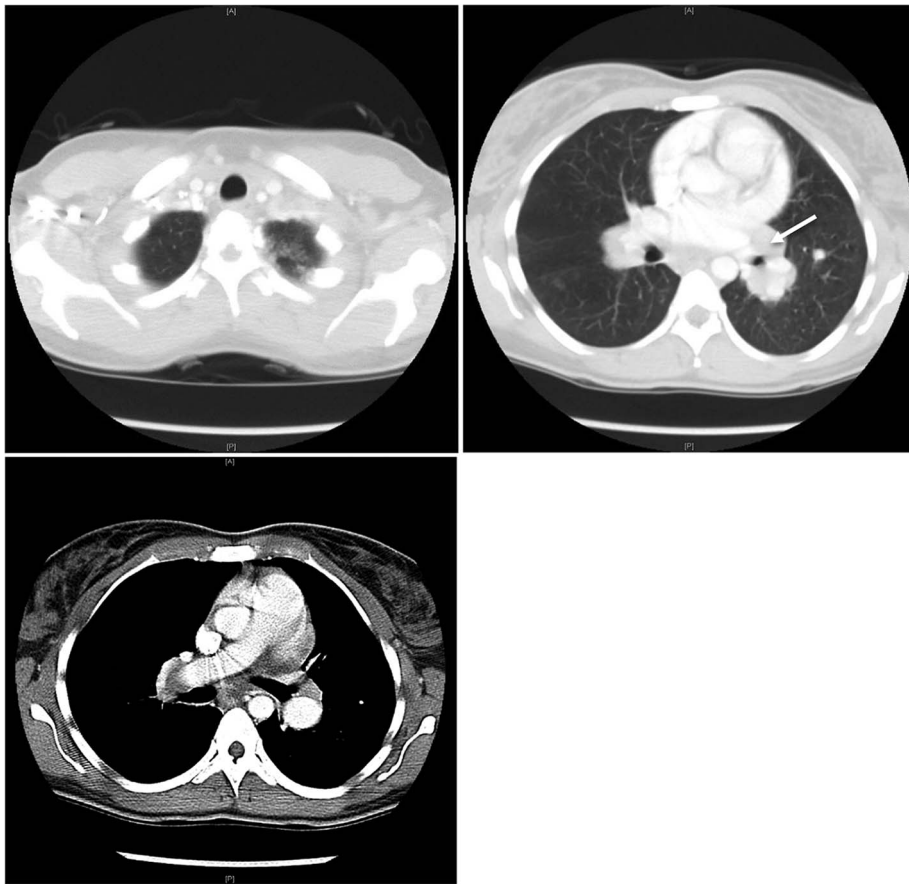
CT scan at initial presentation showing upper lobe infiltrates, hilar lymphadenopathy, and enlarged pulmonary artery.
